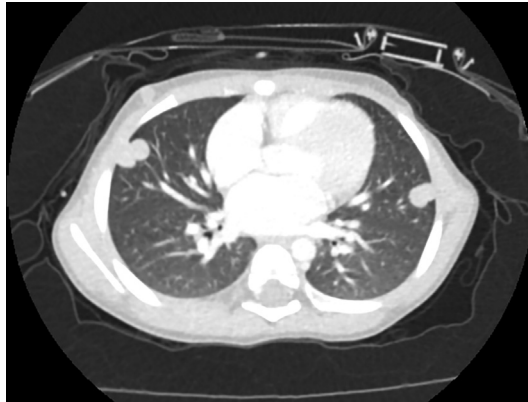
CT scan of a pulmonary metastatic lesion in a patient with WT.
